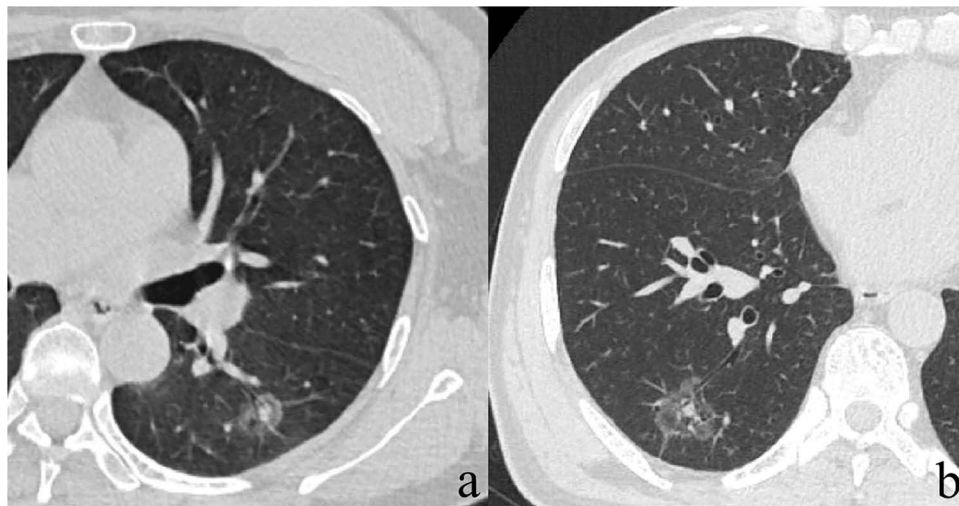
(a) A 54-year-old male of pathologically confirmed moderately differentiated IAC without LNM. A transverse thin-section non-enhanced CT image shows a large (14 mm), well-defined PSN located in the left lower lobe, with the solid component completely surrounded. (b) A 60-year-old male of pathologically confirmed moderately differentiated IAC without LNM. A transverse thin-section non-enhanced CT image shows a large (25 mm), spiculated, well-defined PSN located in the right lower lobe, with the solid components completely surrounded.
